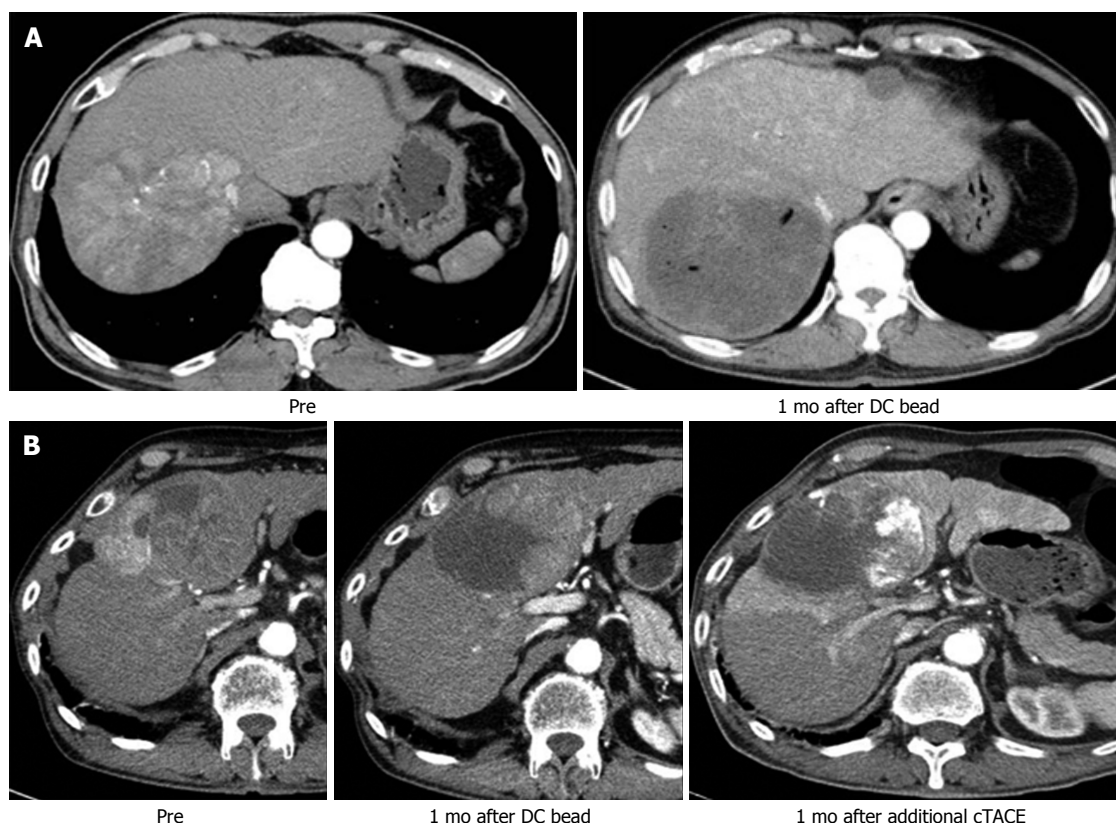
Difference of imaging finding between transarterial chemoembolization with drug-eluting bead and conventional transarterial chemoembolization. A: Two nodular hepatocellular carcinomas (HCCs) with arterial enhancement showed the total necrosis of HCC in follow-up liver dynamic CT after treating with DC bead; B: Nodular HCC showed nodular arterial enhancing viable portion within the partial necrosis of HCC in follow-up CT after treating with DC bead. After additional conventional transarterial chemoembolization (TACE), incomplete lipiodol uptake in remained HCC showed the matched lesion in the CT imaging. CT: Computed tomography.
